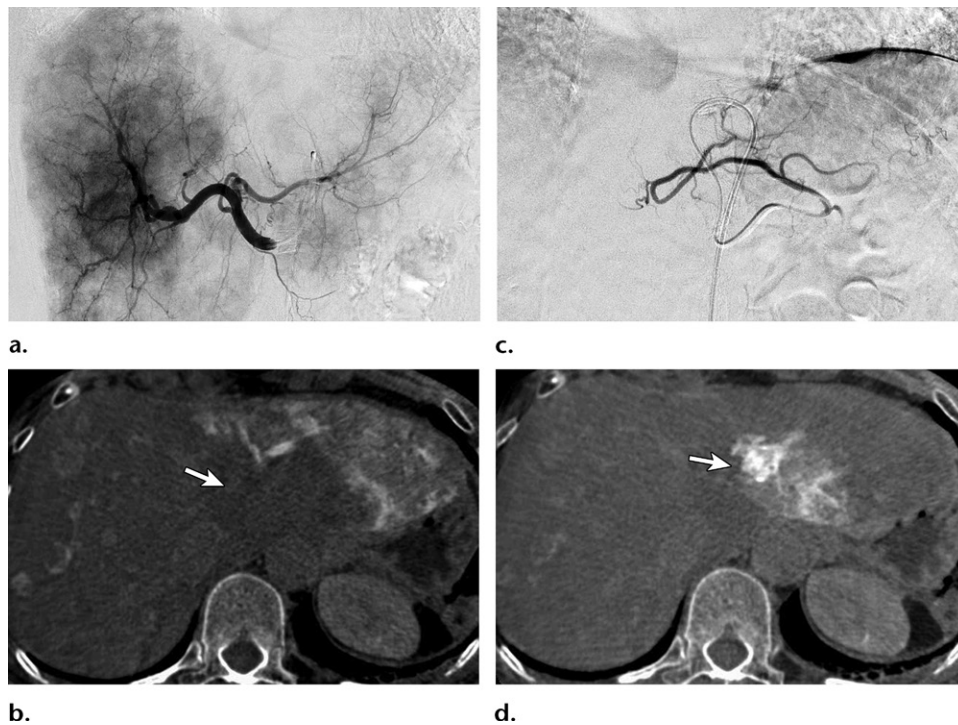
Vascular planning and mapping before treatment of bilateral hepatic metastases of pancreatic neuroendocrine tumor. (a) Hepatic angiogram shows the liver arterial supply; the segment II artery is not visualized. (b) Axial cone-beam CT image obtained during contrast agent injection in the segment III artery shows a lack of enhancement (arrow) in the medial portion of the targeted left tumor. (c) Left gastric angiogram shows the origin of the segment II artery, vascular supply of that segment, and missing sector of the left tumor. (d) Axial cone-beam CT image obtained during selective contrast agent injection in the segment II artery better depicts the missing sector of the left targeted tumor (arrow). This image does not show stomach enhancement and thus enables safe injection of the ^{90}Y spheres.
